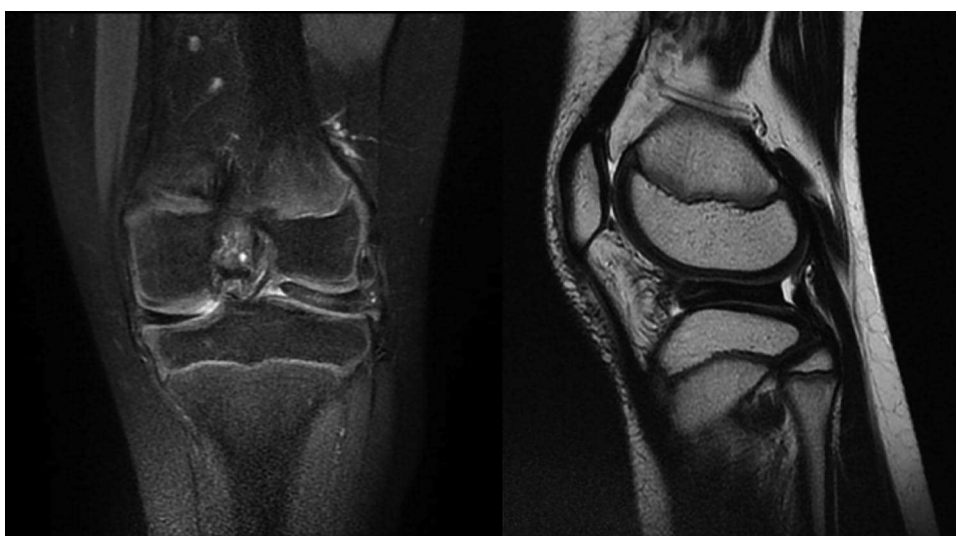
Magnetic resonance imaging (MRI) of the knee of a 9-year-old girl, with a history of a snapping left knee. FAT SAT Coronal (left) and T2 Sagittal (right) MRI views show a complete discoid meniscus with intrasubstance degenerative changes.
